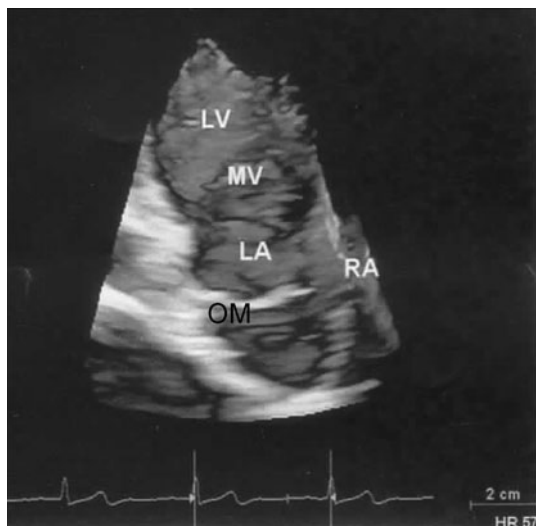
Parasternal long-axis view of the heart. LA = left atrium; LV = left ventricle; MV = mitral valve; OM = obstructive membrane; RA = right atrium
